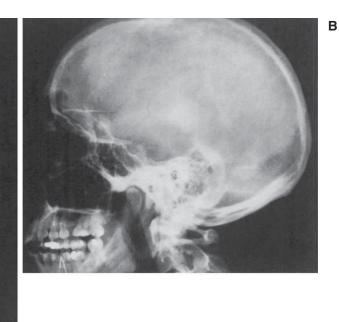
Cranial roentgenograms, in anteroposterior (A) and lateral (B) projections. (Courtesy Barry B. Goldberg, M.D., and Daniel A. Merton, B.S.; R.D.M.S., Department of Radiology, Jefferson Medical College, Philadelphia, Pa.)
